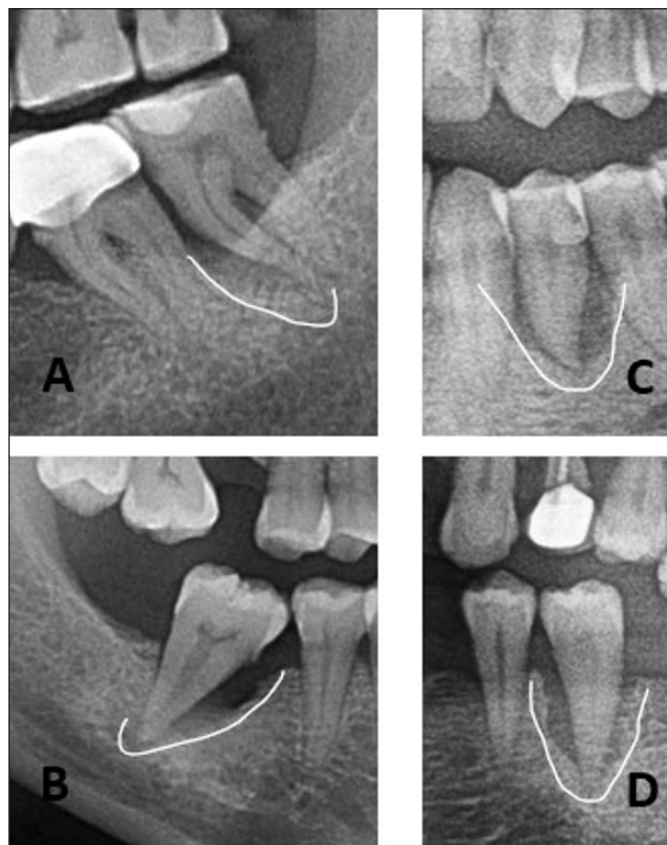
Different radiographic images: j-shape (A-B) and cone-shape (C-D)
